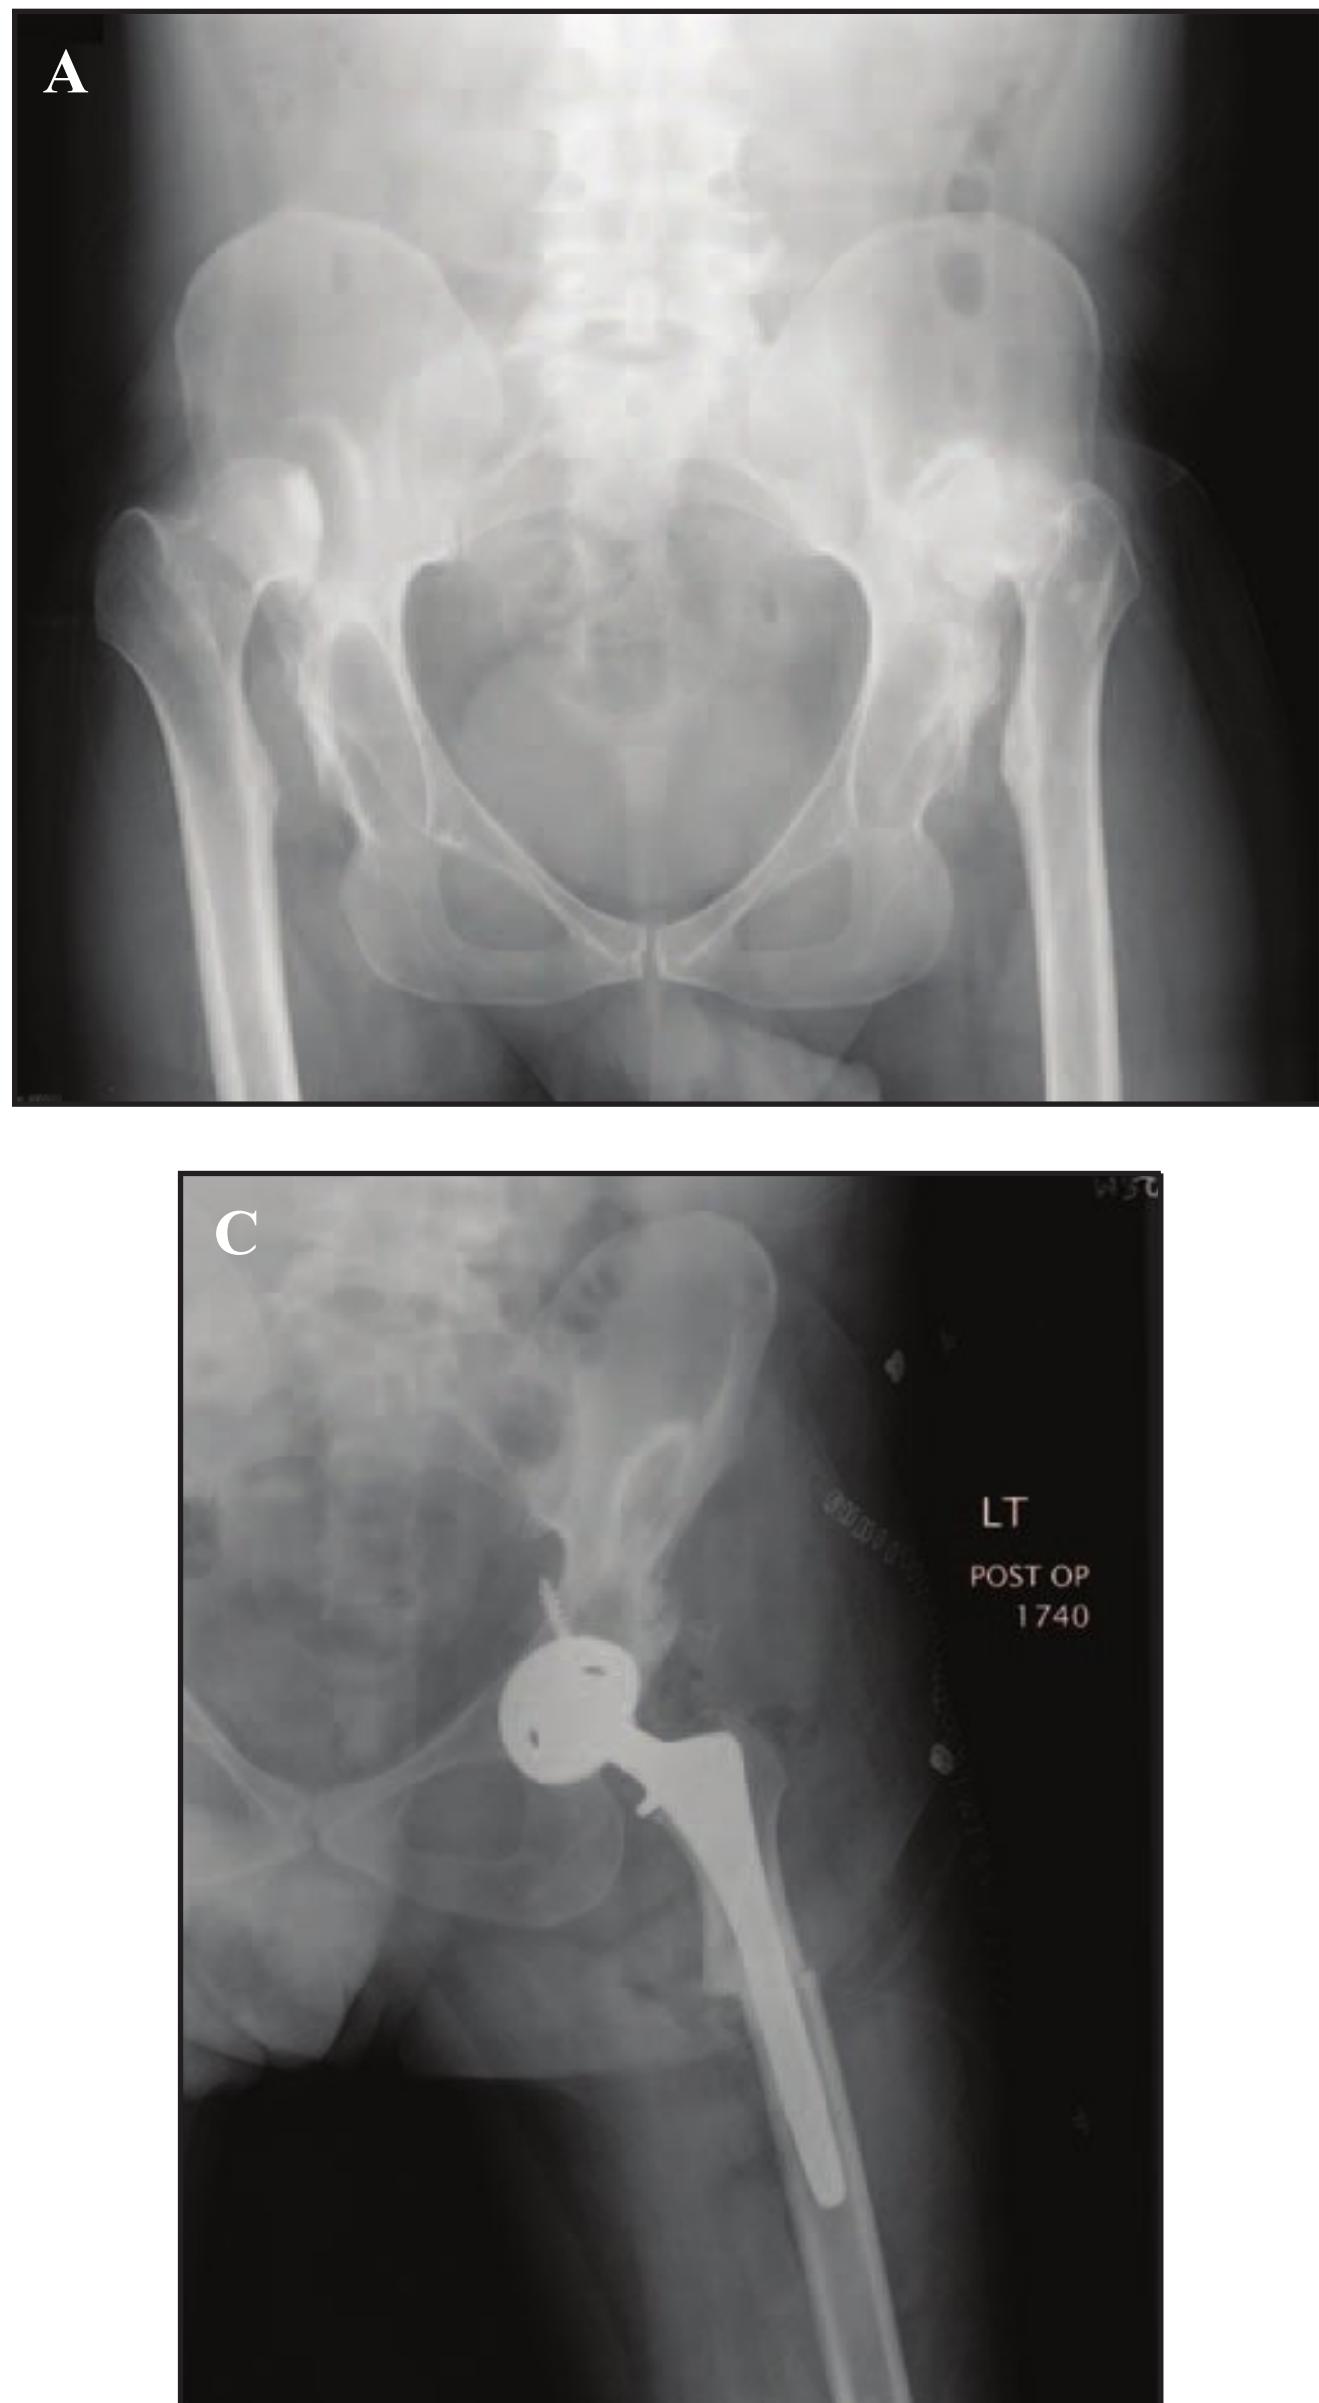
(A) AP radiograph of a 62-year-old male with a history of previous proximal femoral osteotomy. (B) Lateral radiograph of the same patient. (C) Postoperative AP radiograph of the left hip after conversion to THA and supplemental fixation with a cortical allograft strut and cerclage cables.
